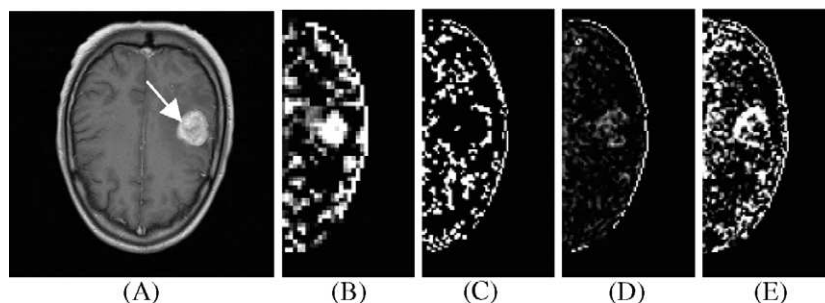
(A) T1 MR image with contrast agent. Also shown are positive FD difference results for (B) PMBC32A, (C) PMBC64, (D) PTPSA64A and (E) Blnt64A.
